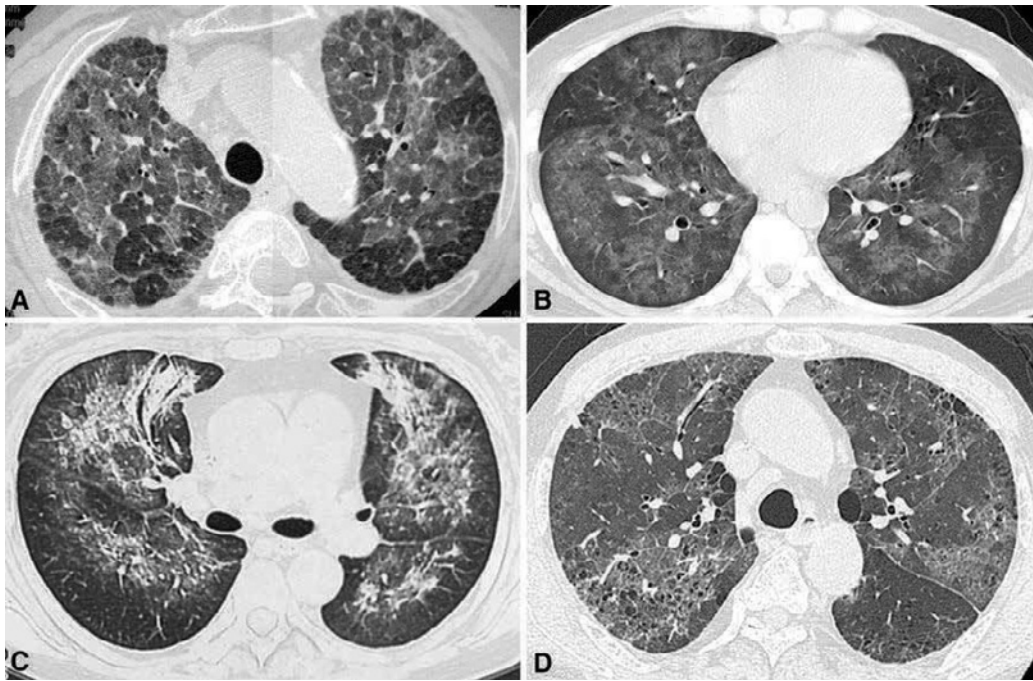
High-resolution computed tomography findings of *Pneumocystis jirovecii* pneumonia (PCP). a PCP in a patient with rheumatoid arthritis receiving methotrexate therapy. Diffuse ground-glass opacity (GGO) is distributed in a panlobular manner, in which GGO is sharply demarcated from the adjacent lung by interlobular septa. b PCP in a patient with human immunodeficiency virus (HIV) infection. Diffuse GGO is distributed in an inhomogeneous manner
